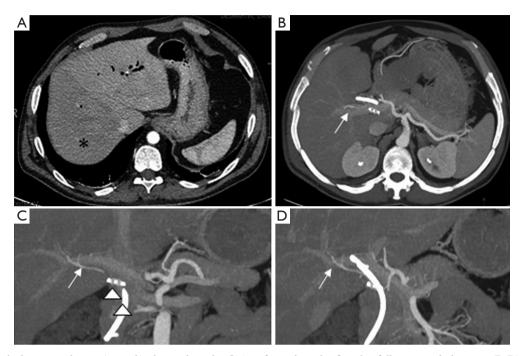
(A) Right hepatic ischemia (asterisk) observed on the CT performed on the first day following embolization; (B-D) a follow-up CT carried out three weeks after embolization demonstrated the development of a collateral system arising from the left branch and revascularizing the right liver lobe (arrow), and postembolization RHA by a plug (headarrow). RHA, right hepatic artery; CT, computed tomography.
